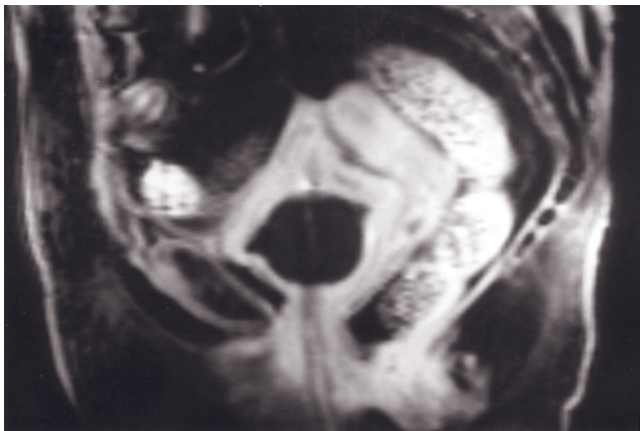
(Continued) postgadolinium fat-suppressed 3D-GE (j) images demonstrate transitional cell cancer in another patient with atrophic kidneys and renal transplant located in the right lower quadrant. The bladder wall is diffusely thickened, and there are multiple polypoid projections extending into the lumen. The thickened bladder wall and its projections show homogenous enhancement on postgadolinium image (j). The tumor does not extend beyond the limits of bladder wall. Intact low-signal-intensity muscular wall deep to the tumor is appreciated on T2-weighted image.
